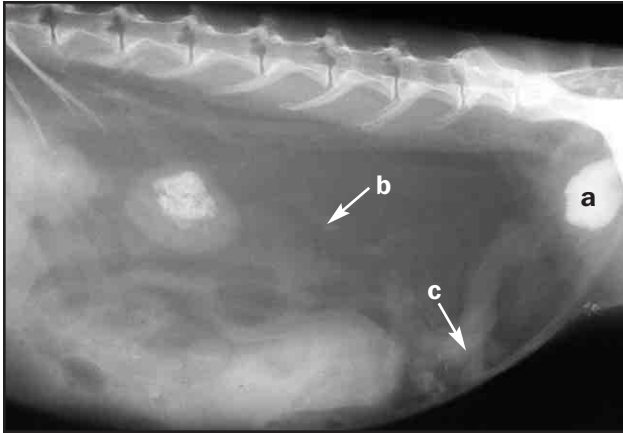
In cases of unilateral nephrolithiasis, an intravenous excretory pyelogram may give a relative indication of renal function. Shown is a lateral radiograph taken 15 minutes after injection of contrast medium. The contrast has already been excreted into the urinary bladder (a), indicating normal function of at least one kidney. The right ureter (b) also appears normal. Radiodensity of the vagina (c) is due to reflux of urine from the bladder.
